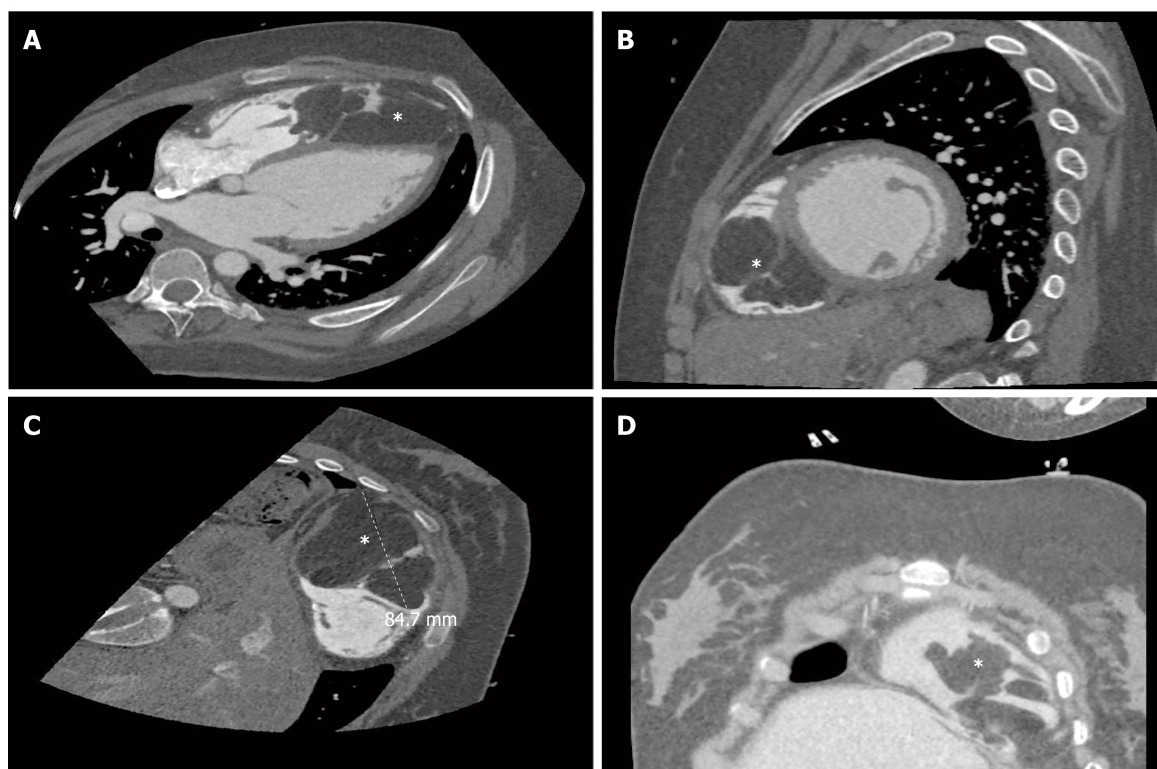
Computed tomography scan. A, B: A mass (star) occupying the right ventricle in axial plane (A), sagittal plane (B); C, D: Atypical plane maximal diameter 84 mm (star).
